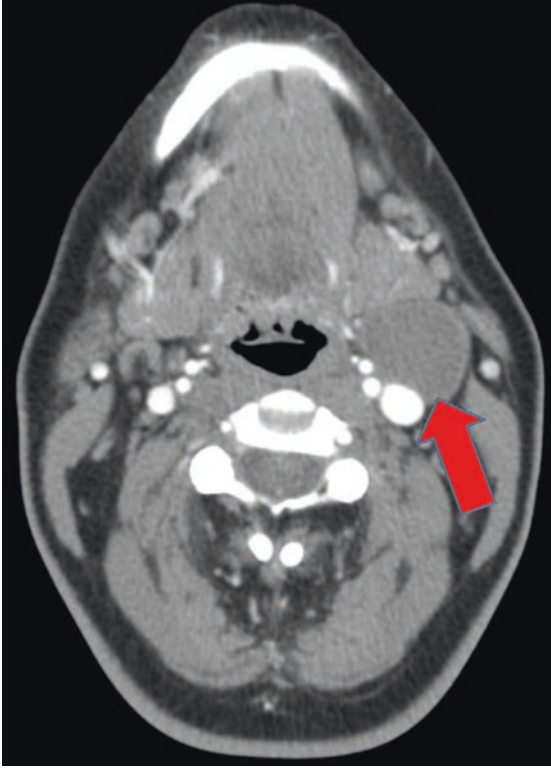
Axial contrast CT image of a congenital branchial cleft cyst in left level II of the neck. Note the lesion may be confused with a cystic lymph node and has slight mural wall thickening (arrow), likely due to previous infection
